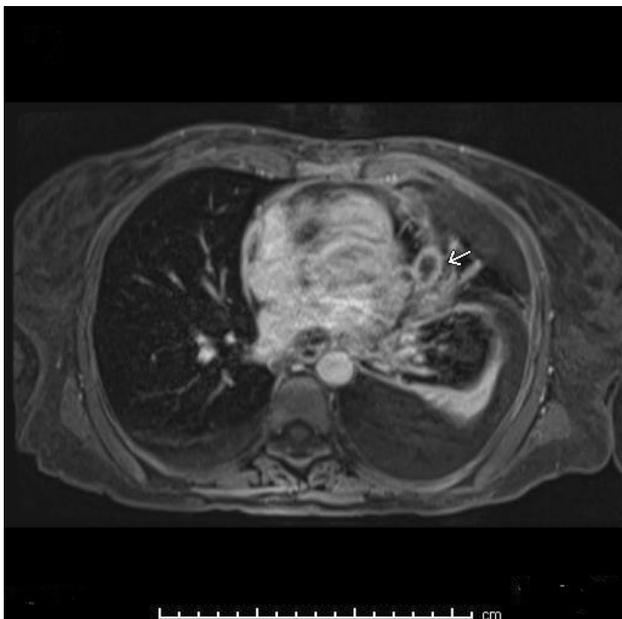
On T1-weighted image with intravenous contrast, the pericardial lesions show ring enhancement, finding interpreted as infected lesions
